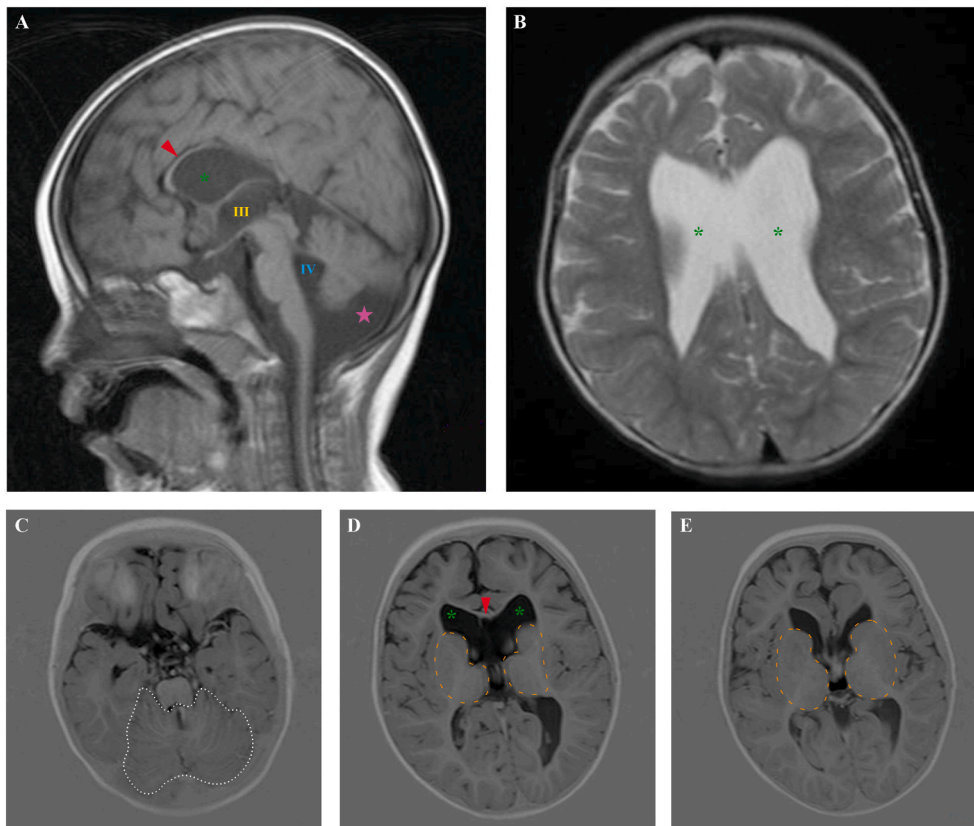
Brain MRI displays structural brain abnormalities. Sagittal (A) and axial (C–E) T1-weighted and axial T2-weighted (B) MR images of the brain at age 2 years and 2 months show several structural brain abnormalities. There is general enlargement of the ventricular system, mostly affecting the lateral ventricles (indicated by green asterisks; panel A, B, D), but also the third ventricle (indicated by a yellow III; panel A) and the fourth ventricle (indicated by a blue IV; panel A), communicating with a megacisterna magna (indicated by a magenta star; panel A). The corpus callosum is hypoplastic (red arrowhead; panel A, D) and the cerebellum and cerebellar vermis show dysplasia, with abnormal morphology and orientation of folia (dotted white line; panel C). The basal ganglia and thalami are dysplastic, with an abnormal round appearance, and individual structures cannot be distinguished clearly (dashed orange line; panel D, E). Additionally, there is a reduced volume of supratentorial white matter (globally seen in panel B, D, E). (For interpretation of the references to colour in this figure legend, the reader is referred to the Web version of this article.)
